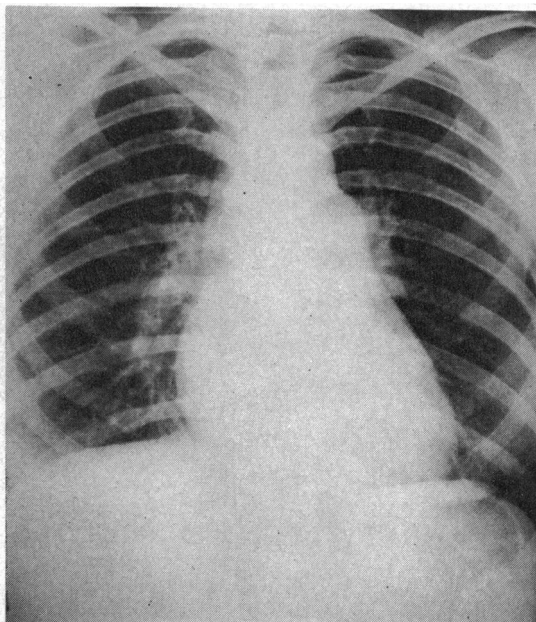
Chest x-ray film from Case 1 showing enlargement of the pulmonary arterial segment.
